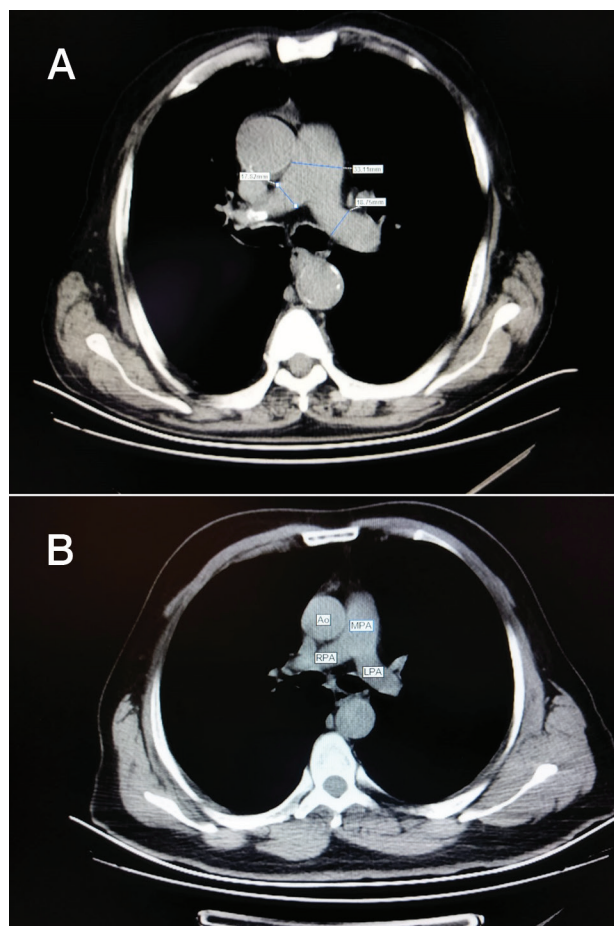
A-B: From chest CT the diameter of the main, left and right pulmonary artery was measured at the level of bifurcation on the mediastinal window
